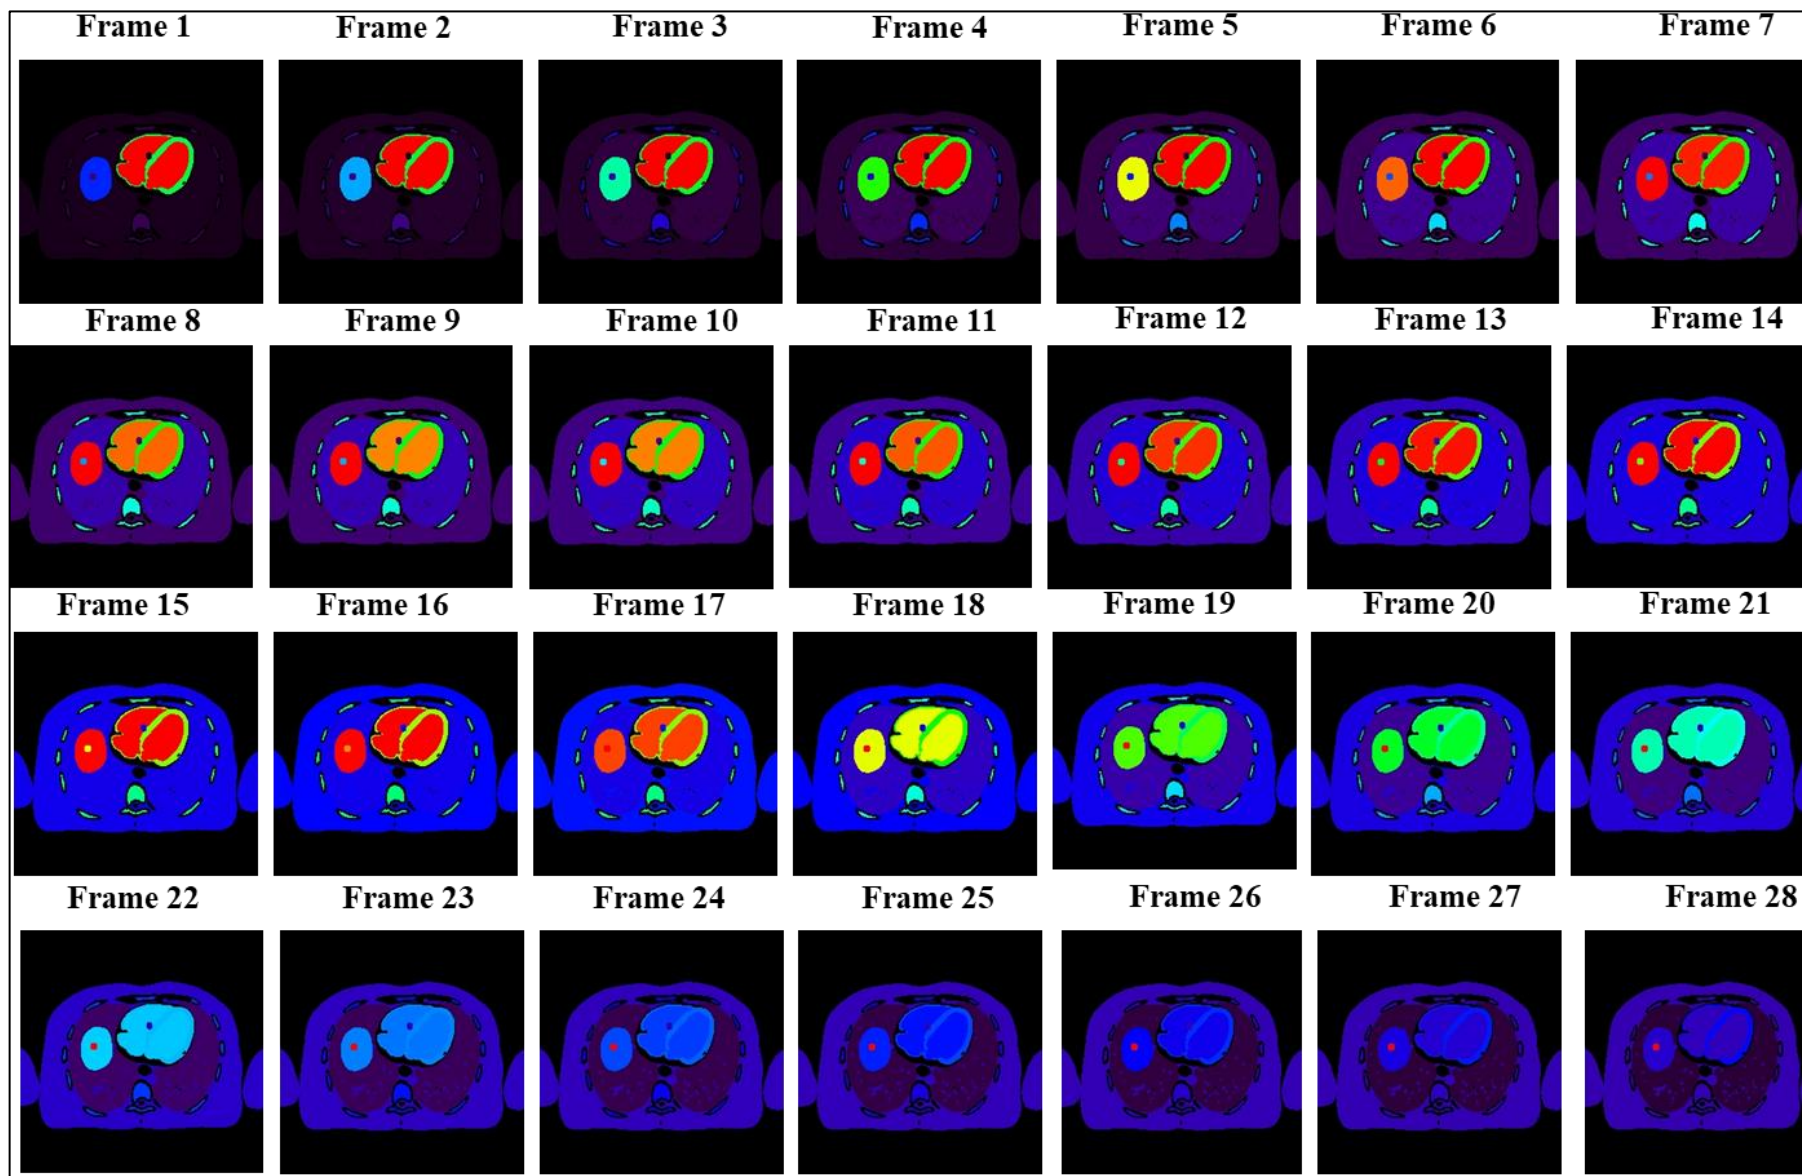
Transverse slices at the liver level selected from all frames of the activity maps showing the distribution of the concentration of ^{18}F -FDG in the lesion and other tissues.
